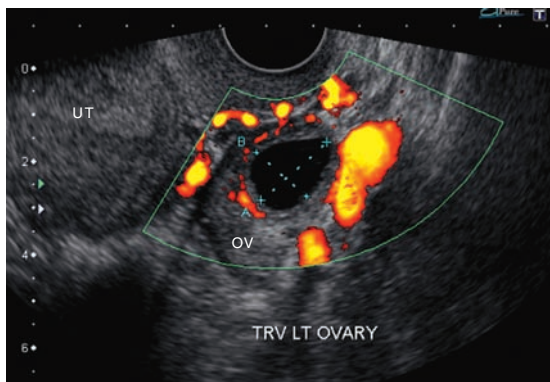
Ovarian cyst mimicking adnexal ring in ectopic pregnancy. Endovaginal view demonstrates an ovarian cyst (within calipers) with color Doppler flow partially around the ovary (OV). This appearance can mimic an adnexal ring seen in ectopic pregnancy. UT—uterus.
